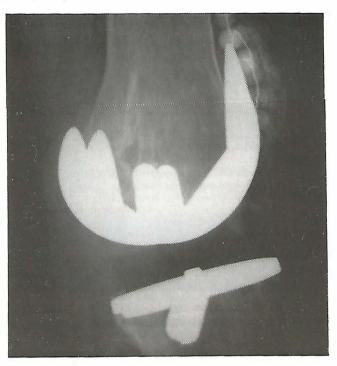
X-rays after antibiotic beads latera view.
